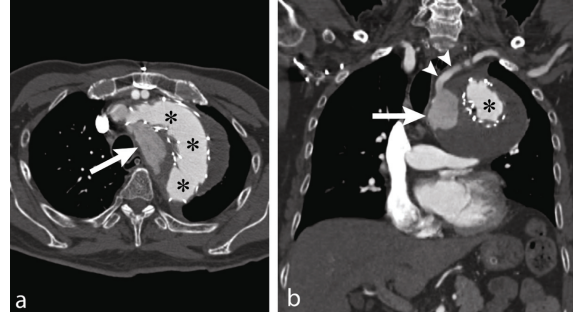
Type II endoleak. axial (a) and coronal (b) CT images of the patient with aneurysm at aortic arch underwent TEVAR (*) with bypass grafts. Large amount of contrast leakage is detected in both central and peripheral (arrows), which is feeded from left subclavian artery (arrow heads)
